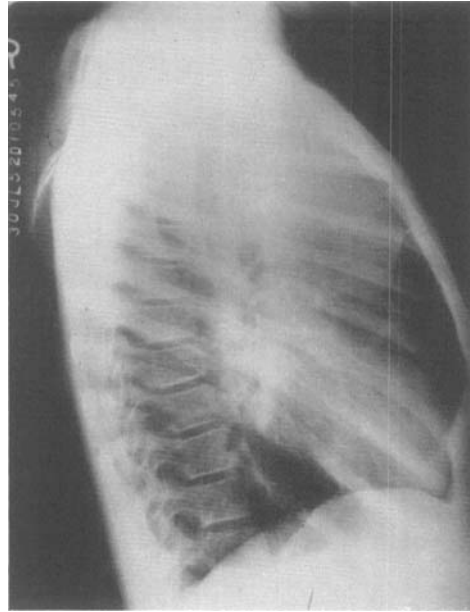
Case 1. Lateral radiograph.
